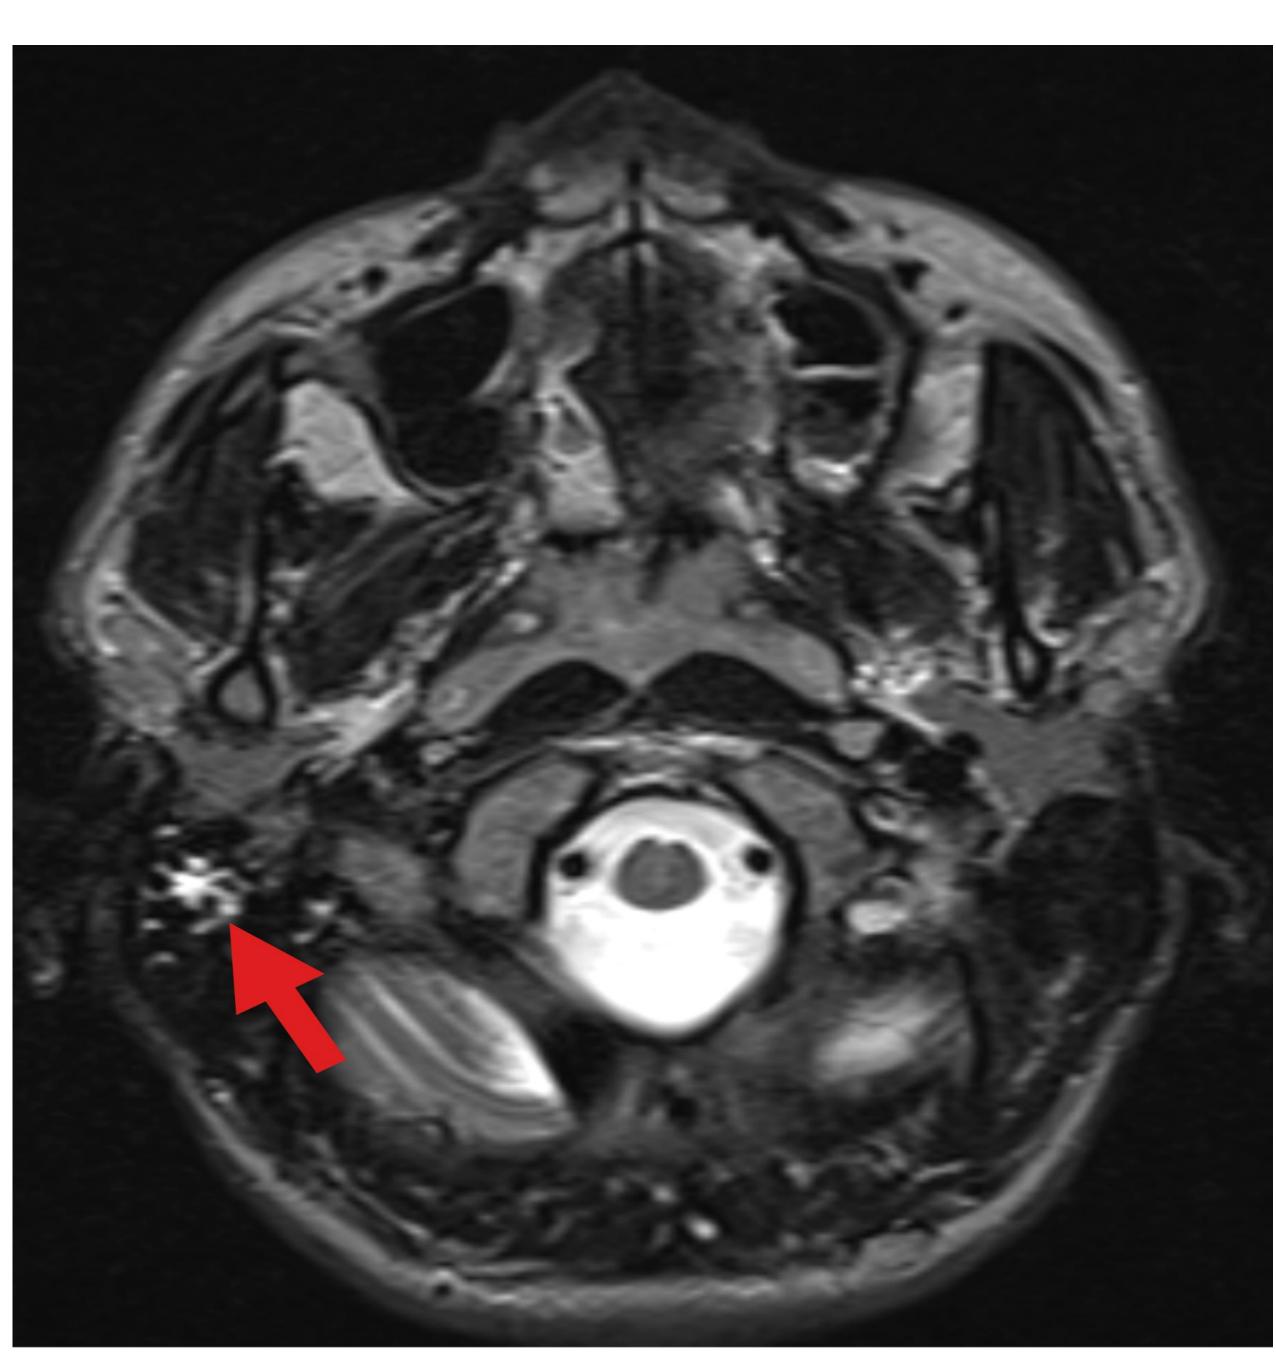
MRI of patients meeting ICHD-3 criteria for migraine. Hyperintensity was noted upon examination of the mastoid region (red arrow) on the same side as the patient's aural fullness and headaches.
